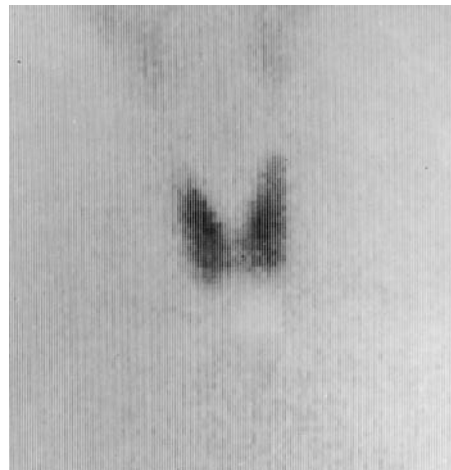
TSH-induced thyrotoxicosis in a 33-year-old woman. Laboratory values were as follows: free T4 = 2.0 ng/dL, T3 = 191 ng/dL, and TSH = 37.1 μ IU/mL. The latter measurement was repeated, and the value was 39.0 μ IU/mL. Anterior distant Tc-99m pertechnetate image shows relatively high target-to-background activity, similar to that seen in Graves disease. CT of the brain performed at an outside imaging center revealed a pituitary tumor. Upon removal of the tumor, the symptoms subsided and thyroid function returned to normal.
